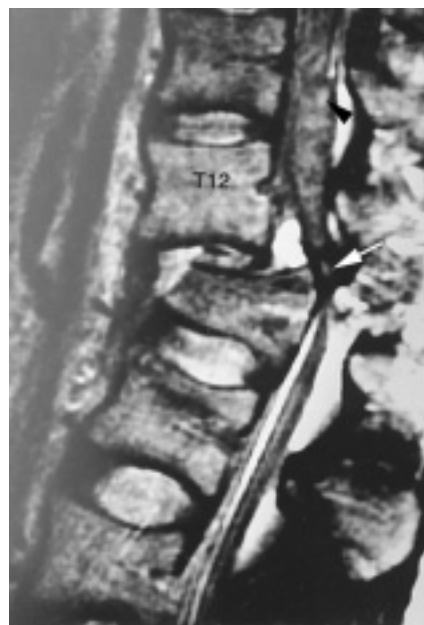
■ Radiograph of Spinal Cord Injury. A crushing blow caused this injury. Note the compression of the cord caused by the posterior displacement of the first lumbar vertebrae. Reprinted with permission from Werner R: *A Massage Therapist's Guide to Pathology*. Ed. 2. Baltimore, MD: Lippincott Williams & Wilkins, 2002, p 213.
